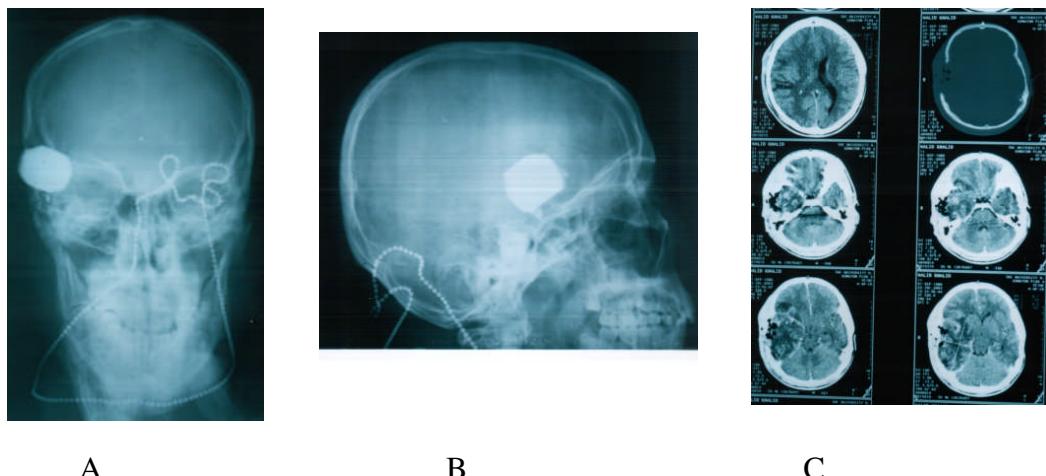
Few radiological pictures of plain skull X-ray and computerized tomography. A. Plain postero-anterior view. B. A lateral view. C. A post-operative CT axial pictures.
